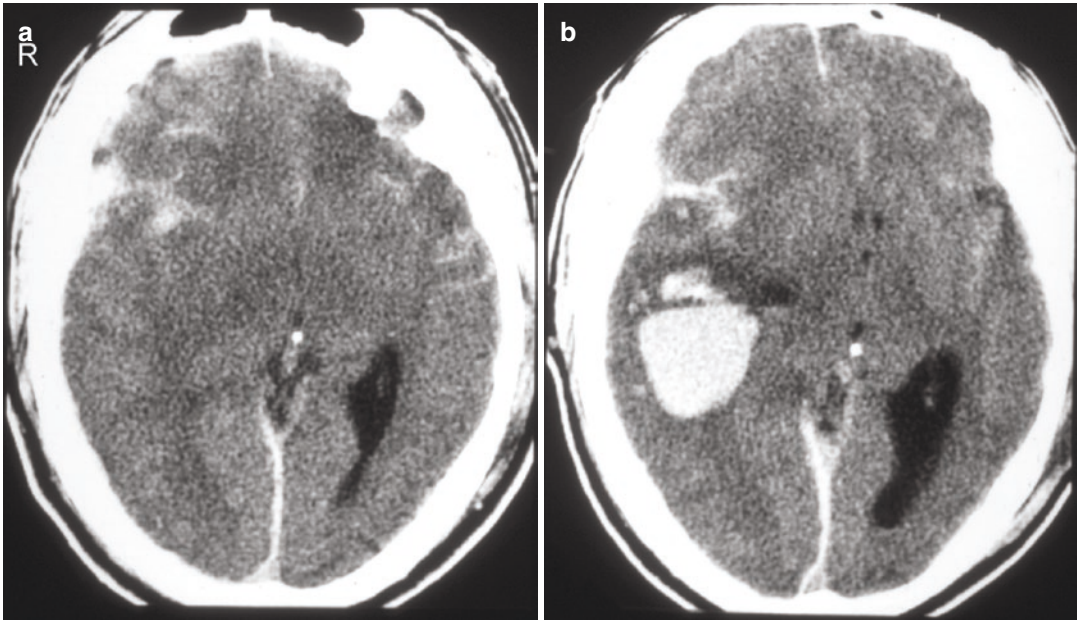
“Delayed” intracerebral hematoma. (a) Non-contrast axial CT scan on admission demonstrates bilateral frontotemporal subarachnoid hemorrhages, right-to-left midline shift, and effacement of the right occipital horn, but without focal mass lesion. (b) The
